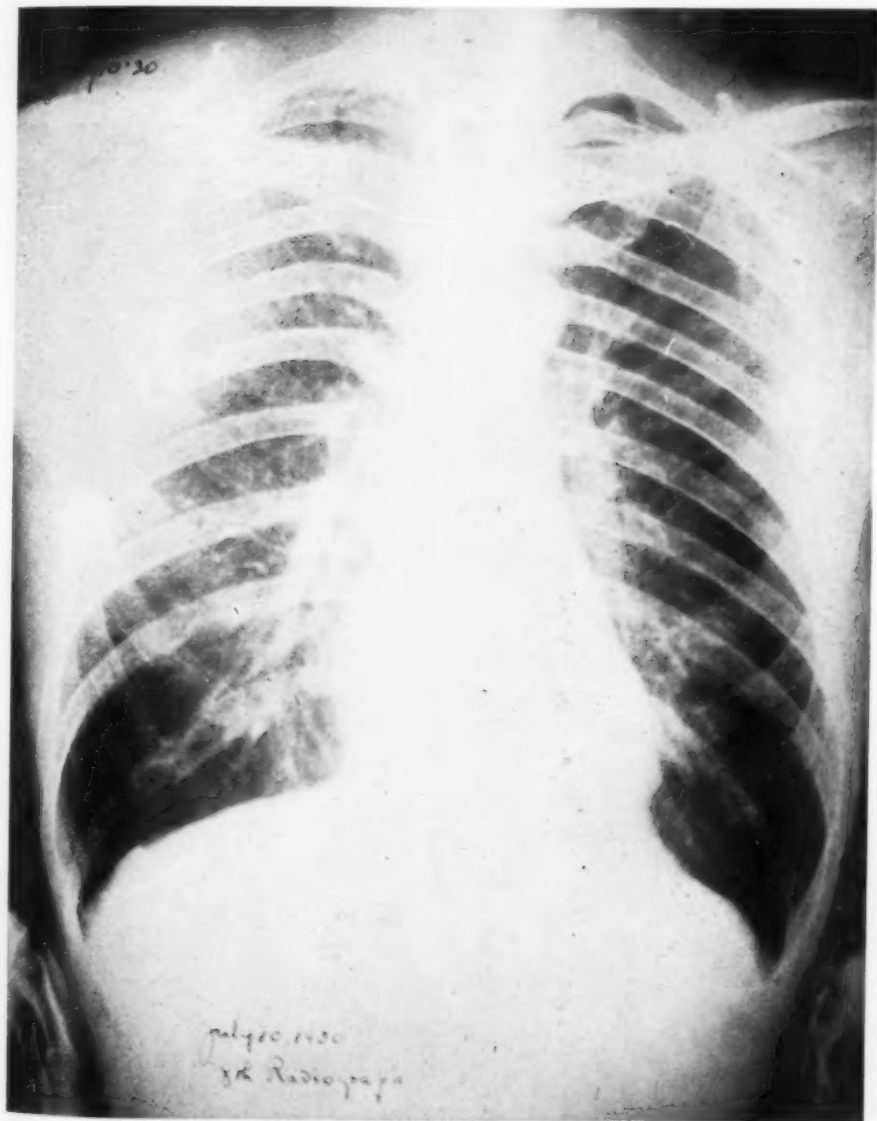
Radiograph of Case No. II seven years after pneumothorax.
